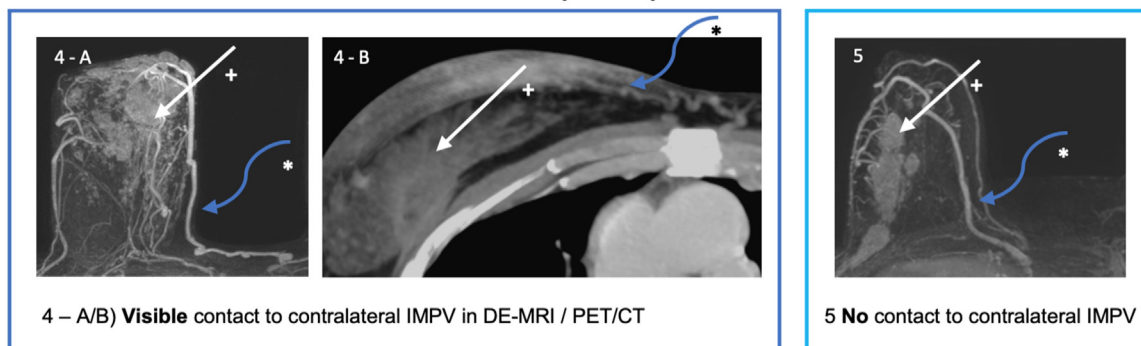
Classification of tumor contact with ipsilateral IMPV: 1. (A) Major iIMPV contact due to multiple side branches, (B) major iIMPV contact due to main branch; 2. Minor iIMPV contact; 3. No visible iIMPV contact; 4. (A) Visible contact with cIMPV in DE-MRI, (B) visible contact with cIMPV on PET/CT; 5. No cIMPV contact. White straight arrows (+) label the breast cancer, blue curved arrows (*) label IMPV. *Abbreviations:* cIMPV = contralateral internal mammary perforator vessels; DE-MRI = dynamic contrast-enhanced magnetic resonance imaging; iIMPV = ipsilateral internal mammary perforator vessels; PET/CT = positron emission tomography/computed tomography.
